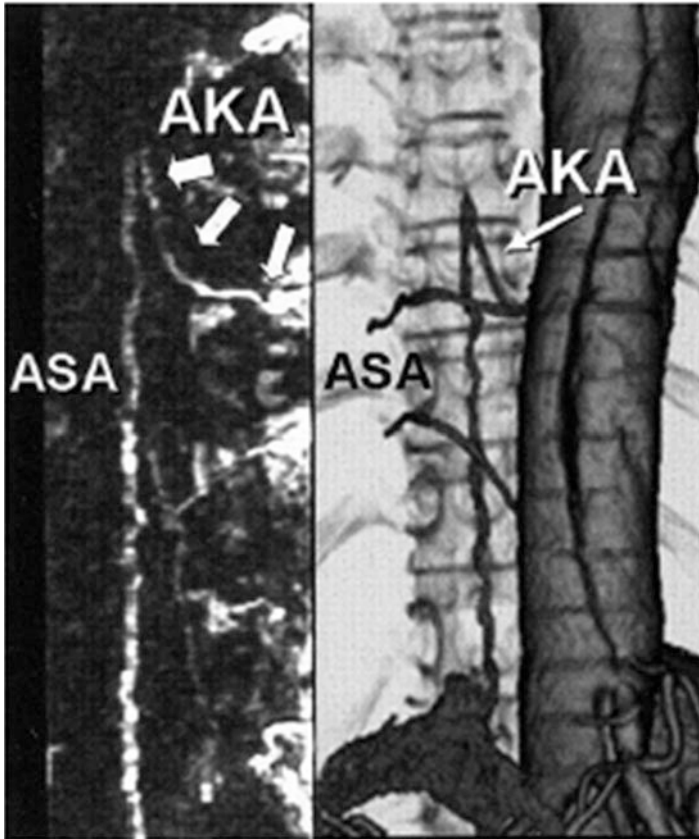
The Adamkiewicz artery (MRA). Magnetic resonance angiography demonstrates the Adamkiewicz artery (AKA [*large white arrows*]) ascending to the anterior midsagittal surface of the spinal cord from the radicular-medullary artery originating from the dorsal branch of the intercostal or lumbar artery. It is continuous with the anterior spinal artery (ASA), with a hairpin turn in the early phase (*left*). The Adamkiewicz artery (*white arrow*) can be visualized clearly by multidetector computed tomography scans as well (*right*). *Ann Thorac Surg* 2006;82:592–6
